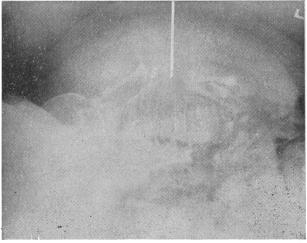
Lateral radiograph, showing that the paracentesis needle is inserted between the flexed arms and legs of foetus.
